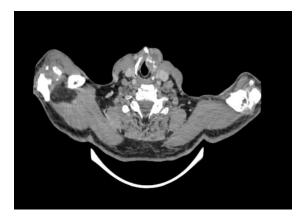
CT Scan showed a ill defined lesion involving the left vocal cord with erosion of the left lamina of thyroid cartilage with extralaryngeal extension.
